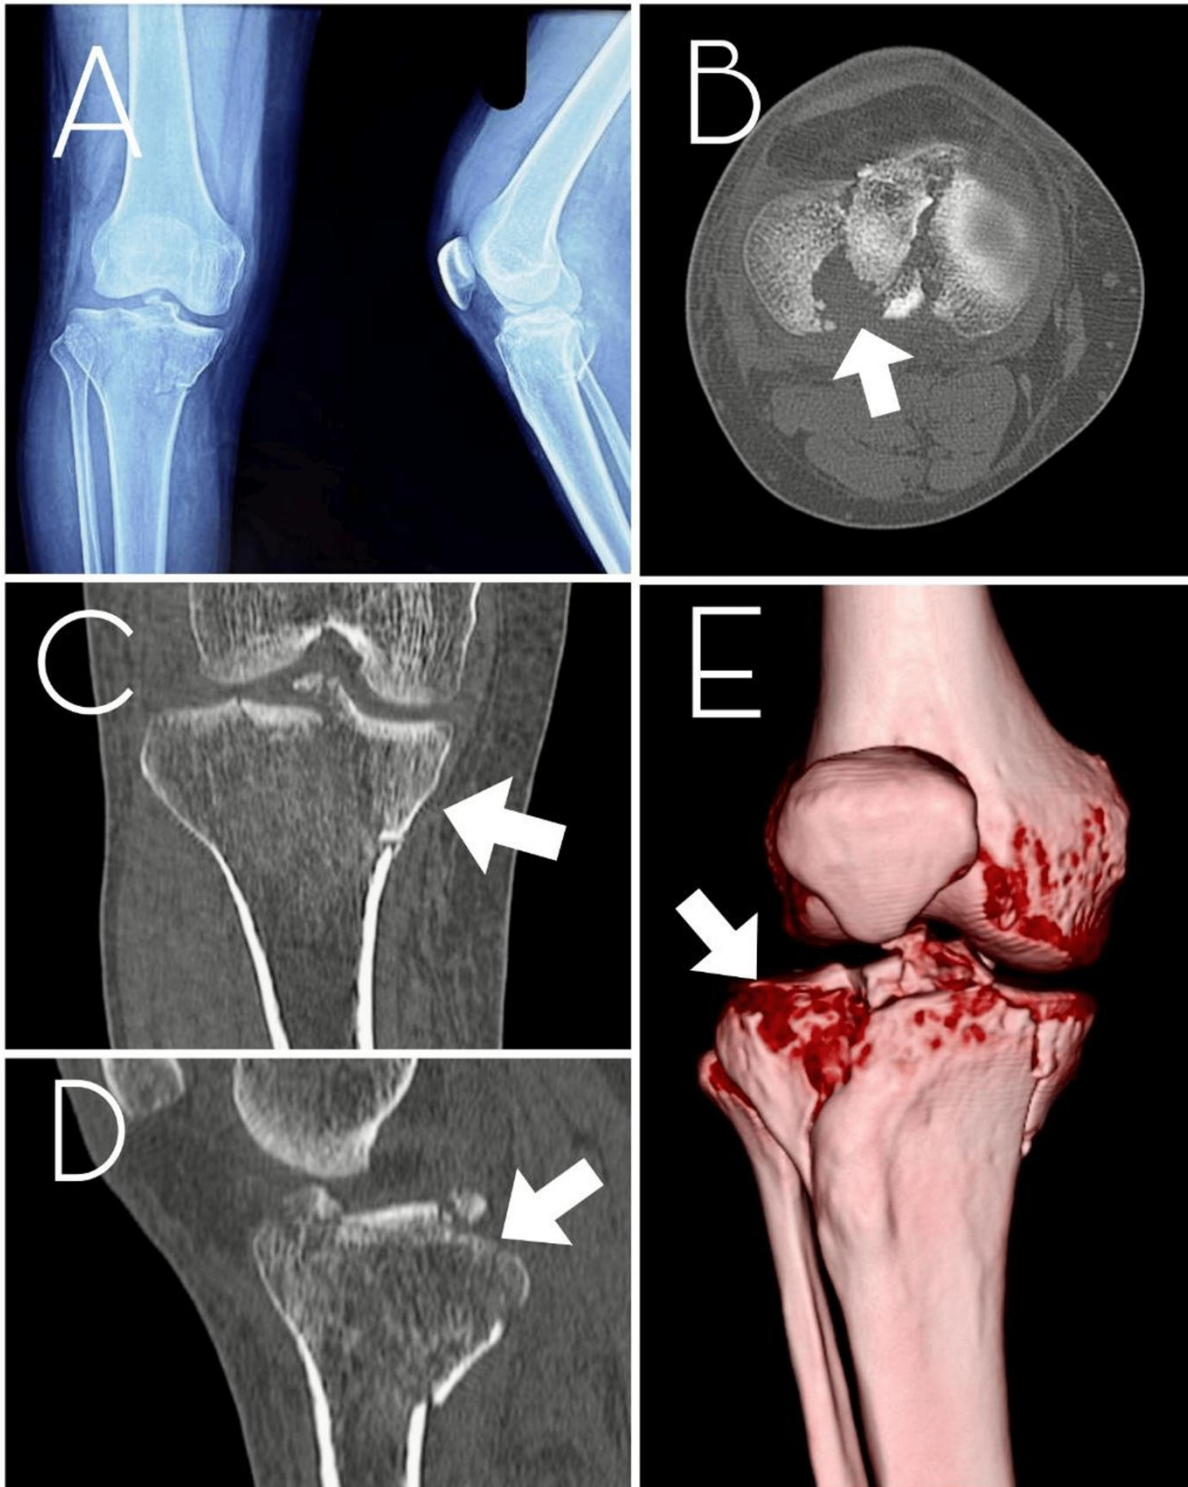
Case-1: pre-operative radiograph and CT views of a 41 year old male patient diagnosed with proximal tibia fracture schatzker type 5.
